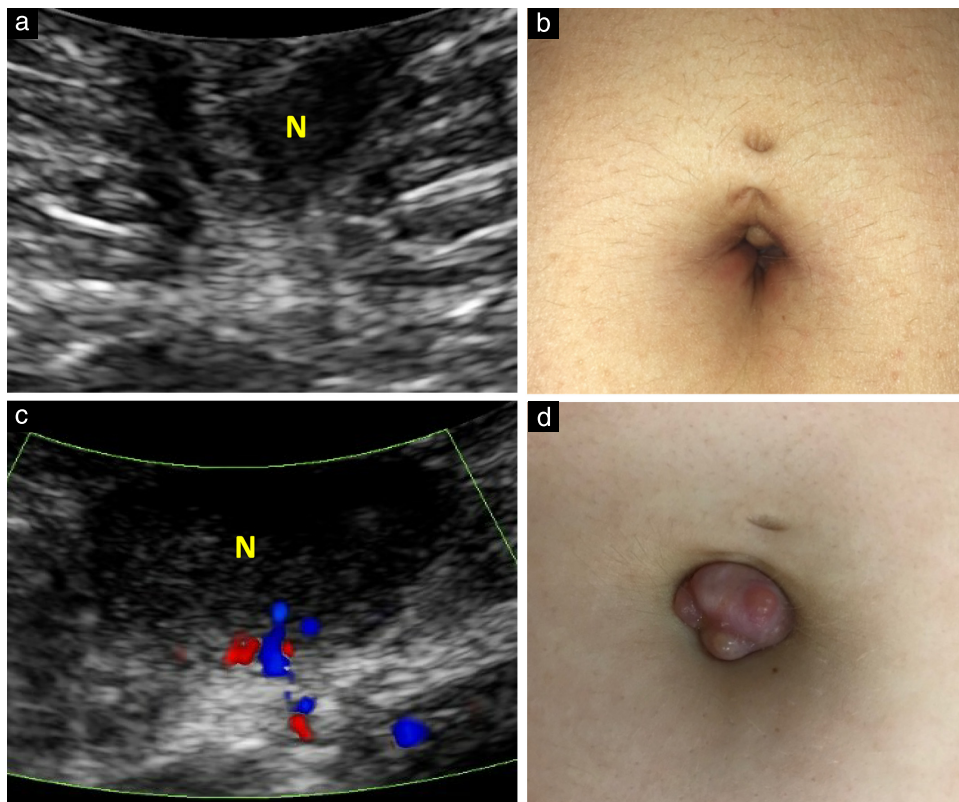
Images in 33-year-old patient with 3-year history of umbilical endometriotic nodule, which caused cyclical bleeding and was confirmed to be endometriosis on biopsy. (a,b) Transabdominal grayscale ultrasound image of umbilicus demonstrating endometriotic nodule (N) measuring 7 mm in mean diameter (a) and corresponding macroscopic appearance (b) prior to pregnancy. (c,d) Transabdominal color Doppler ultrasound image demonstrating increase in nodule size to 21 mm and increased vascularity, in keeping with decidualization (c) and corresponding macroscopic appearance (d) at 18 weeks' gestation.
